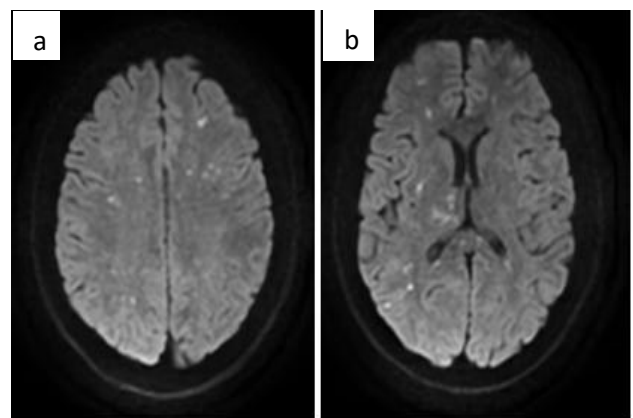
(a, b): Diffusion weighted magnetic resonance imaging with starfield pattern.
